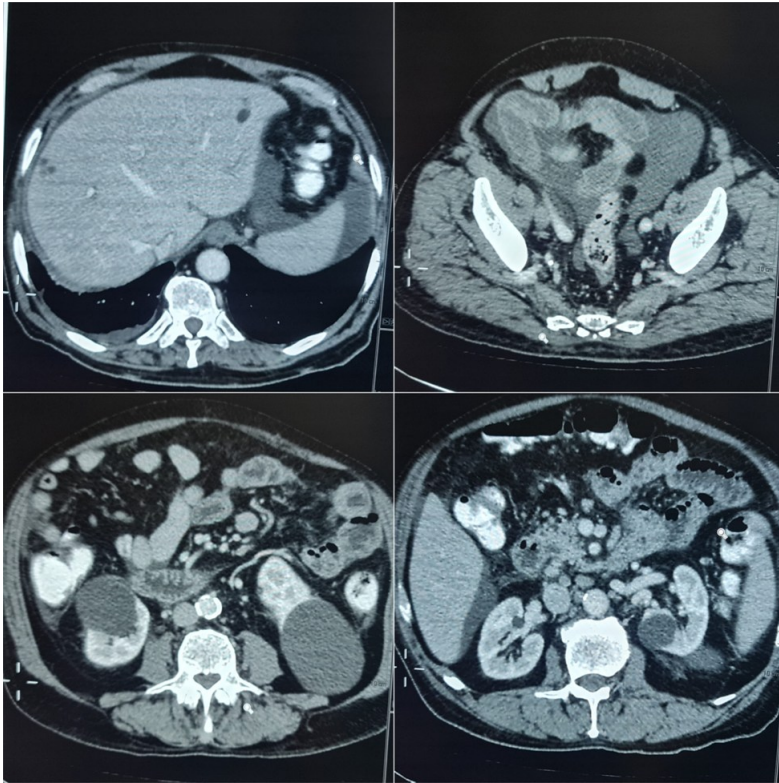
Contrast Enhanced CT showing gastric thickening, ascites, multiple enlarge lymph nodes.
